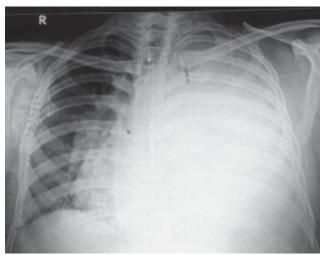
Chest radiograph (postero-anterior view) showing left-sided massive pleural effusion.
